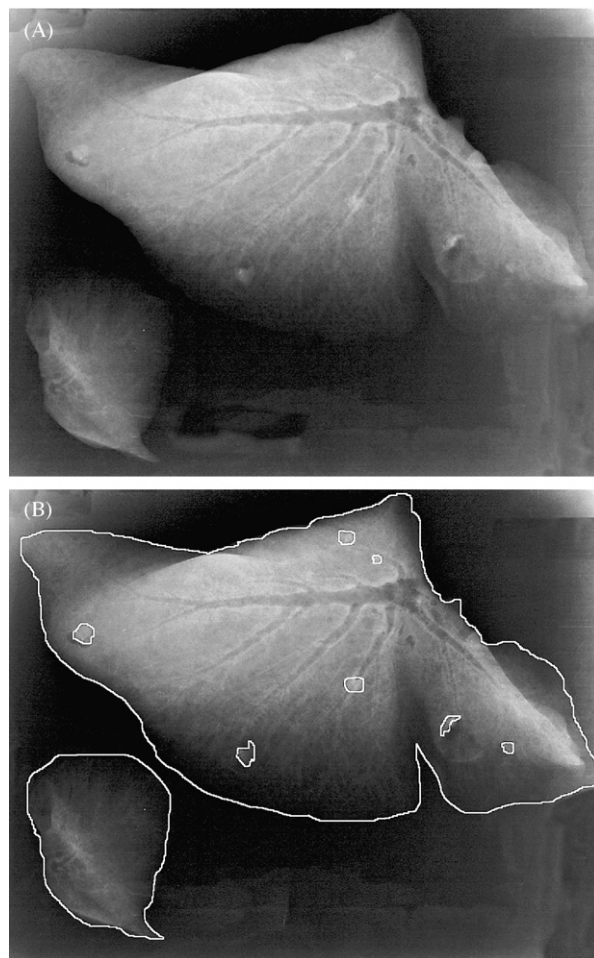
Technique for identifying lung lobe margins and tuberculous lesions on radiographs for morphometry analysis. (A) Lung lobes were removed at necropsy and individually radiographed as described [22]. Right middle and caudal and accessory lung lobes are presented in this image. (B) Lung margins and lesions were outlined and measured using Image Pro Plus (Media Cybernetics) software.
